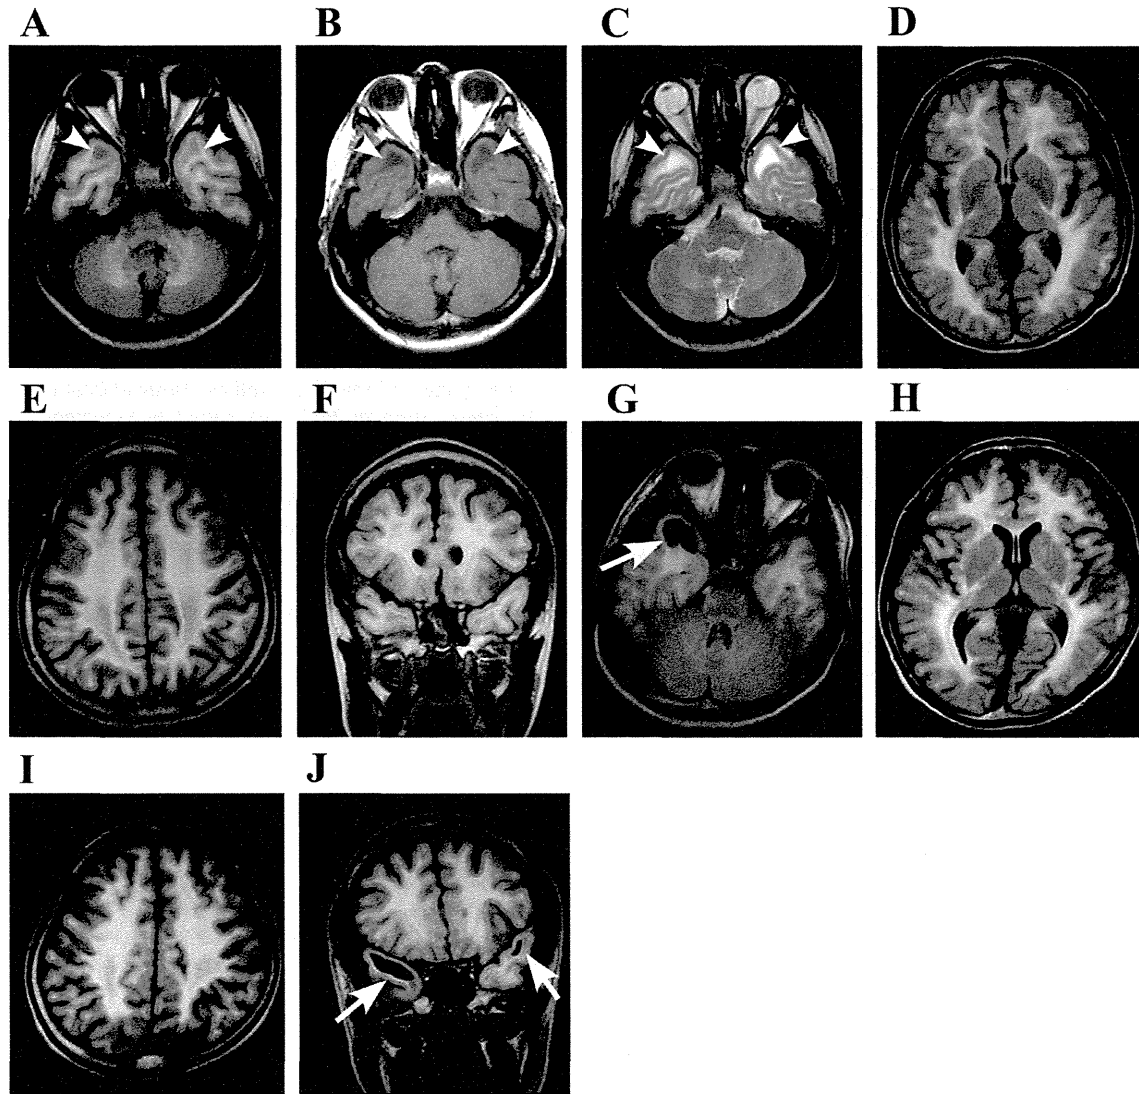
Brain MRI images of the two adult sisters with MLC. (A–F) Case 1 (II-2). (G–J) Case 2 (II-3). (A, D–J) FLAIR images. (B) T1-weighted image. (C) T2-weighted image. Arrows point to subcortical cysts in the anterior temporal region; the arrowheads indicate anterior temporal lesions without cystic changes in MRI.
